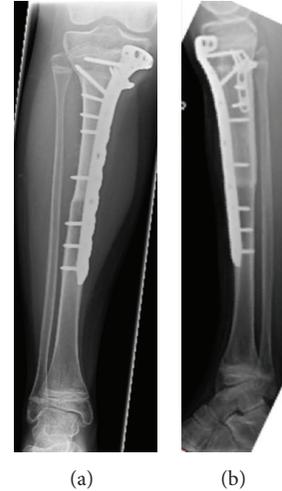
12-year-old boy with EWS sarcoma of the proximal tibia. Result of the reconstruction with preservation of the growth plate: radiographic anteroposterior and lateral view.
